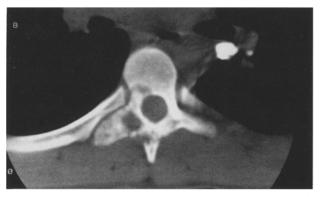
CT scan demonstrating an expansile mixed lytic and sclerotic pheochromocytoma metastasis involving the right posterior elements and posterior vertebral body at the level of T8 in a 30-year-old man (patient 5) who presented with back pain
